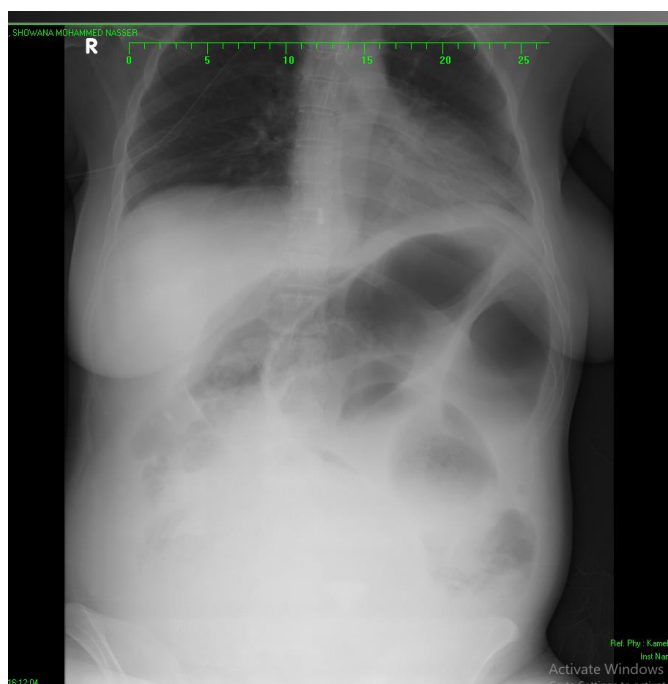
Plain abdominal x-ray – supine position.
